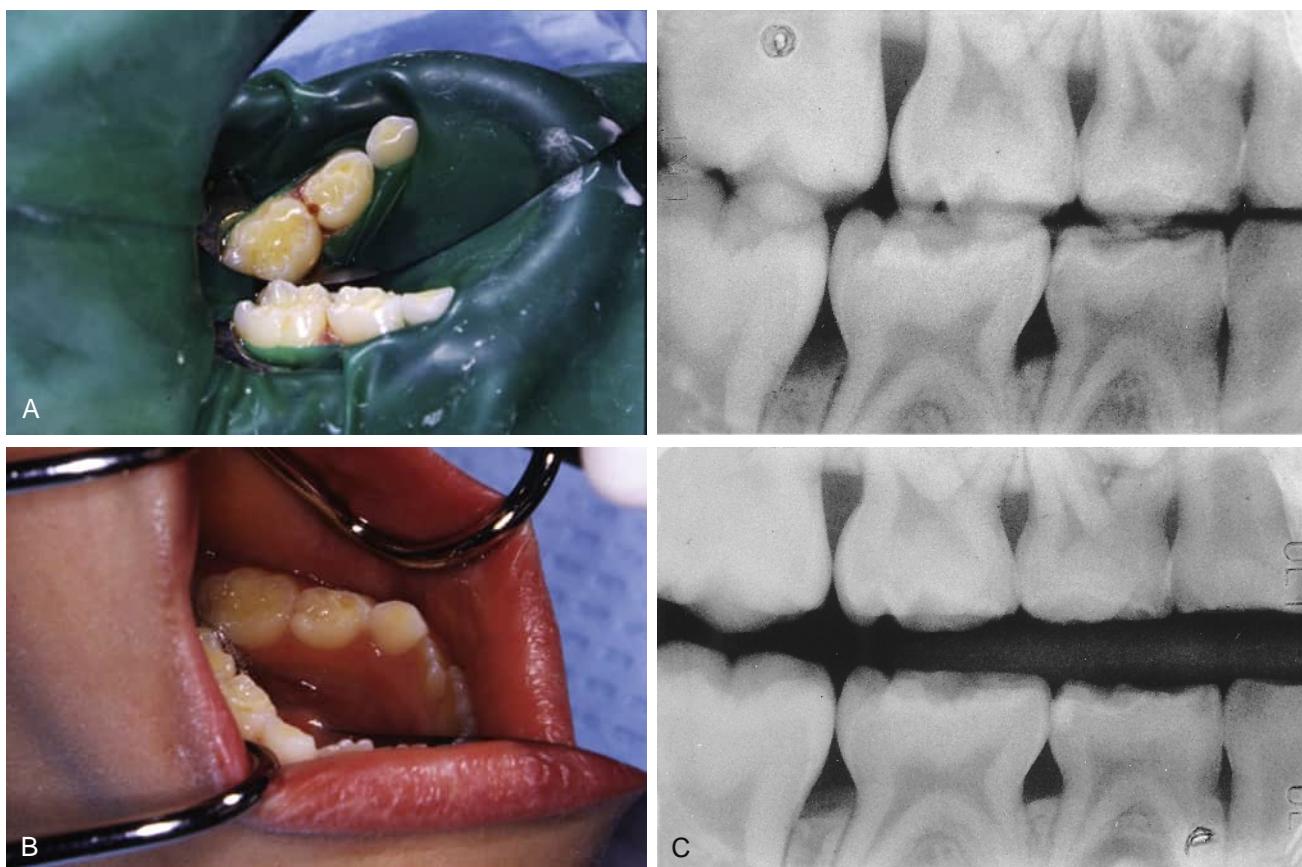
(A) Conservative class II preparation. (B) Resin-modified glass-ionomer restoration. (C) Preoperative radiograph (top) and 17-month postoperative film.
